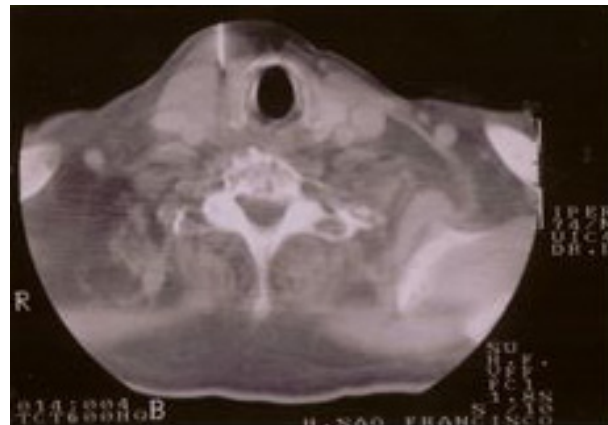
Axial CT scan of the neck showing the CT-guided needle biopsy of the thyroid abscess.
